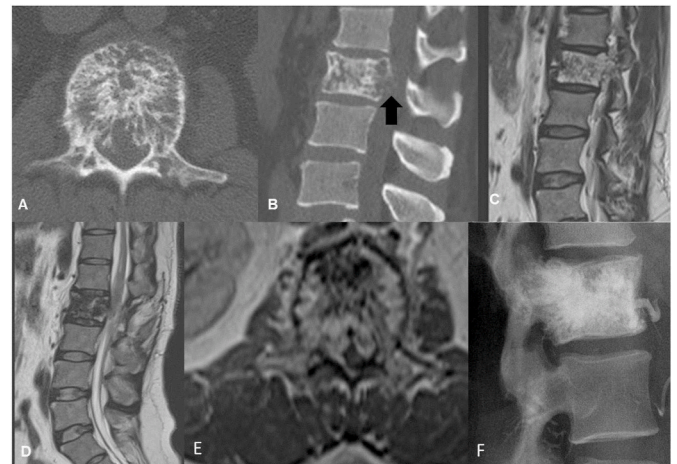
45-year-old male with back pain and no neurological deficits. A: Axial CT non-contrast showing the lesion having a characteristic polka dot appearance. L1 vertebral body was involved by the tumour with thinning of the posterior cortex. (arrow) The sagittal CT shows typical corduroy appearance of the lesion with a small component in the spinal canal. C: Sagittal T2 W MRI showing a hyperintense enhancing lesion involving the entire L1 vertebral body with a small epidural component causing spinal stenosis. D & E: Postoperative laminectomy defect with extrusion of the bone cement into the spinal canal. F: Postoperative X ray showing the leakage of bone cement beyond the vertebral body into the canal.
